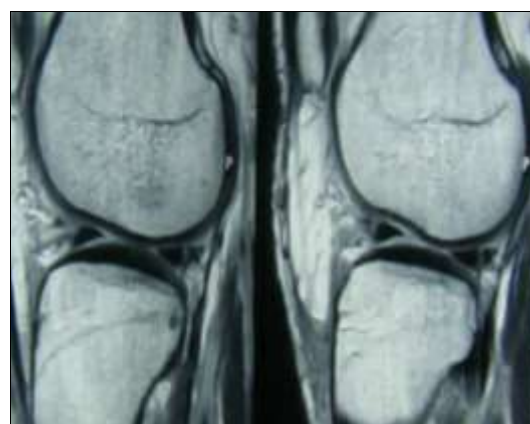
MRI view of longitudinal tear of posterior horn of lateral meniscus
